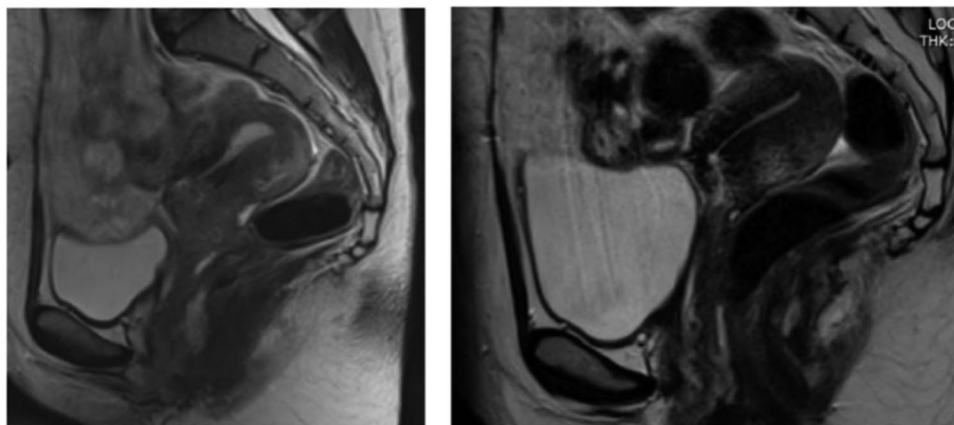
MRI before (left) and after (right) neoadjuvant chemotherapy showing near complete resolution of the lesion.
